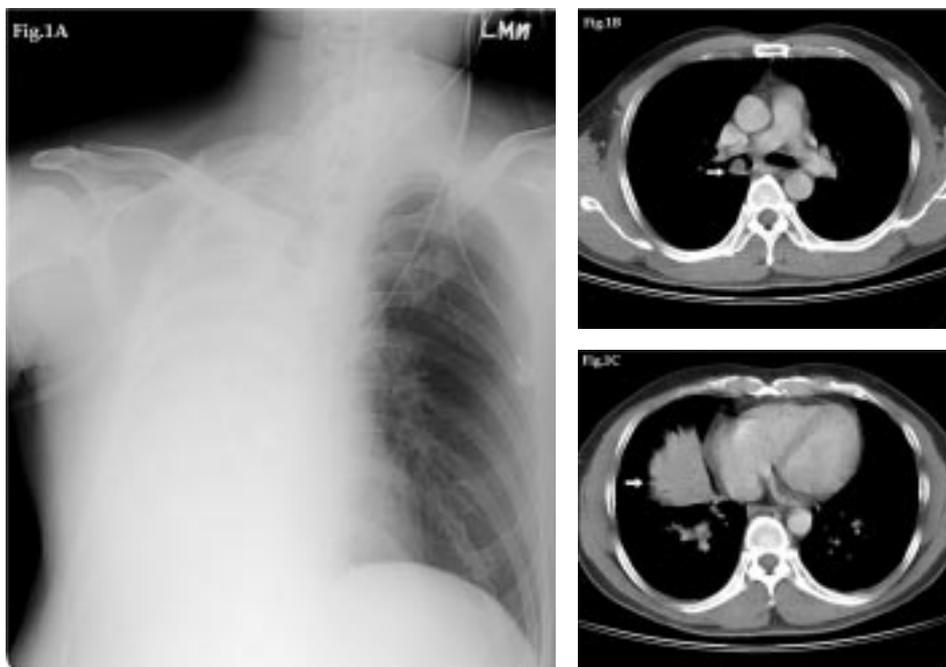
(A) Anterior-posterior (A-P) chest X-ray reveals opacification of the right lung with mediastinal shift to right side. (B) Chest-computed tomography (CT) shows endobronchial tumor in right main bronchus (arrow). (C) Complete atelectasis in right middle lobe (RML) secondary to bronchial obstruction (arrow).
